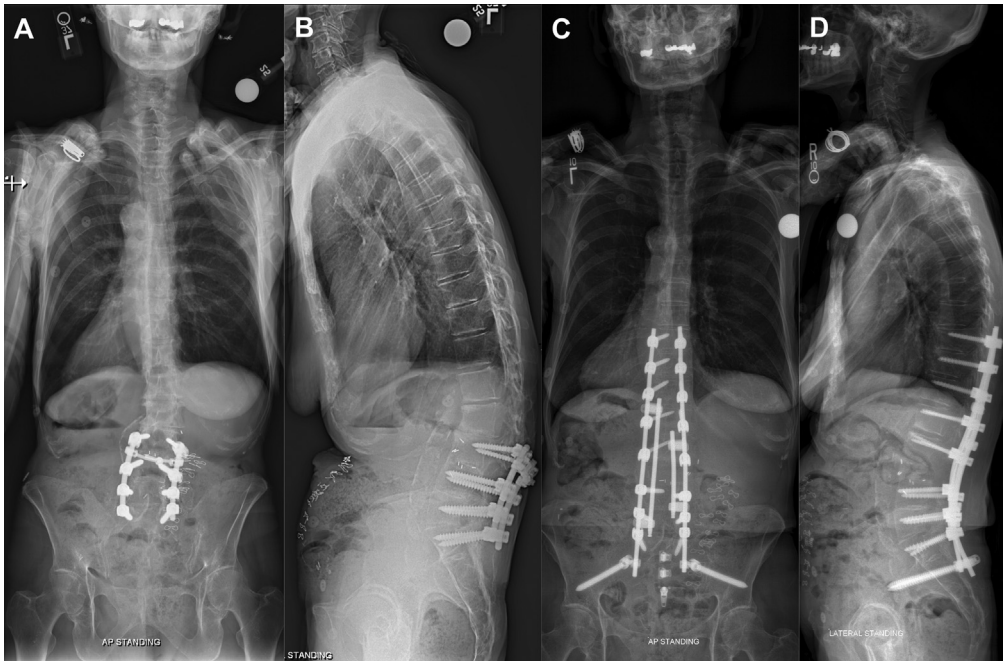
Patient with previous L3-S1 instrumented fusion, associated iatrogenic flatback deformity and proximal junctional kyphosis resulting in significant positive sagittal malalignment (A and B). C, anteroposterior and D, lateral radiographs following posterior instrumented fusion from T10 to the pelvis with L3 pedicle subtraction osteotomy, T12/L1 and L1/2 Smith-Petersen osteotomies show restoration of lumbar lordosis and successful global realignment.
